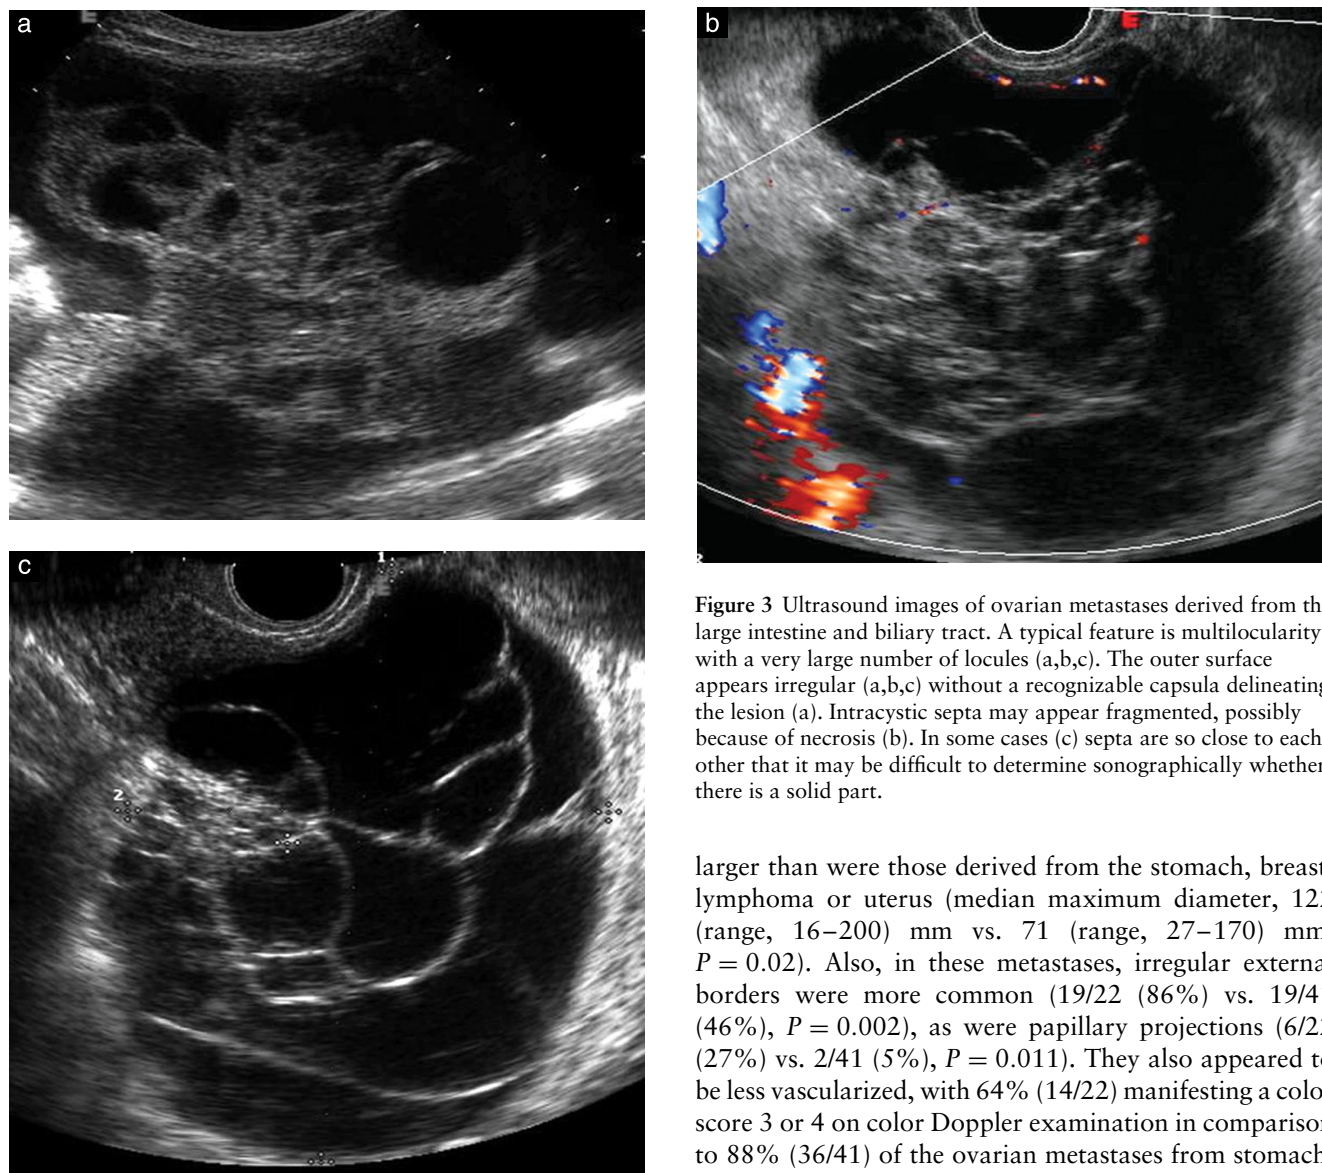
Ultrasound images of ovarian metastases derived from the large intestine and biliary tract. A typical feature is multilocularity with a very large number of locules (a,b,c). The outer surface appears irregular (a,b,c) without a recognizable capsula delineating the lesion (a). Intracystic septa may appear fragmented, possibly because of necrosis (b). In some cases (c) septa are so close to each other that it may be difficult to determine sonographically whether there is a solid part.
